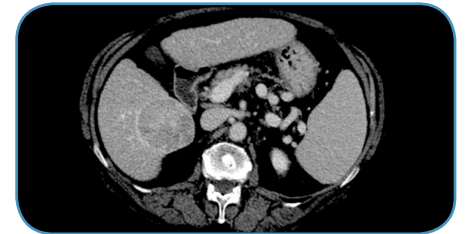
CT image in arterial phase of HCC before treatment
